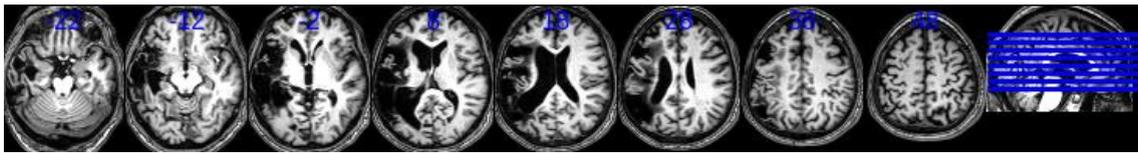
UB12's T1-weighted MRI brain scan.
